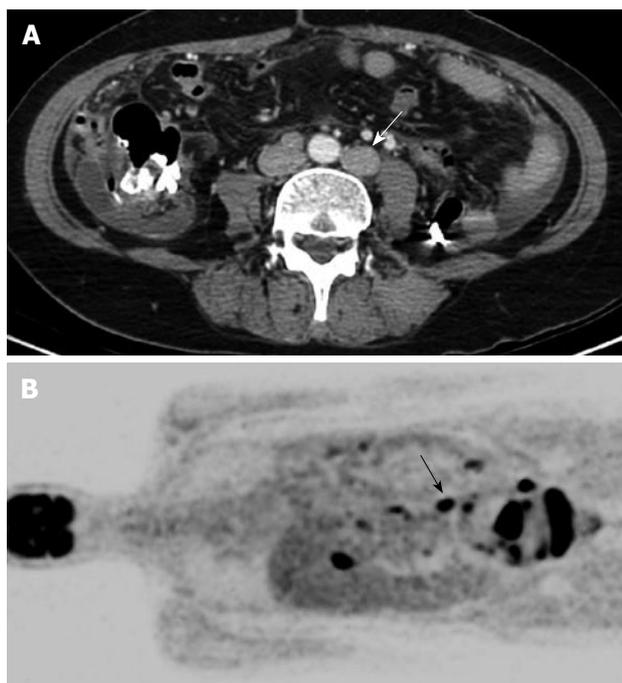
Typical case of metastatic paraaortic lymph node (PAN) on both computed tomography (CT) and positron emission tomography (PET). A 52-year-old woman with ovarian cancer underwent CT and PET. (A) Axial CT scan shows enlarged (short diameter was 16 mm) and conglomerated PAN (arrow) and (B) coronal view of PET image shows positive FDG uptake in this PAN (arrow).
